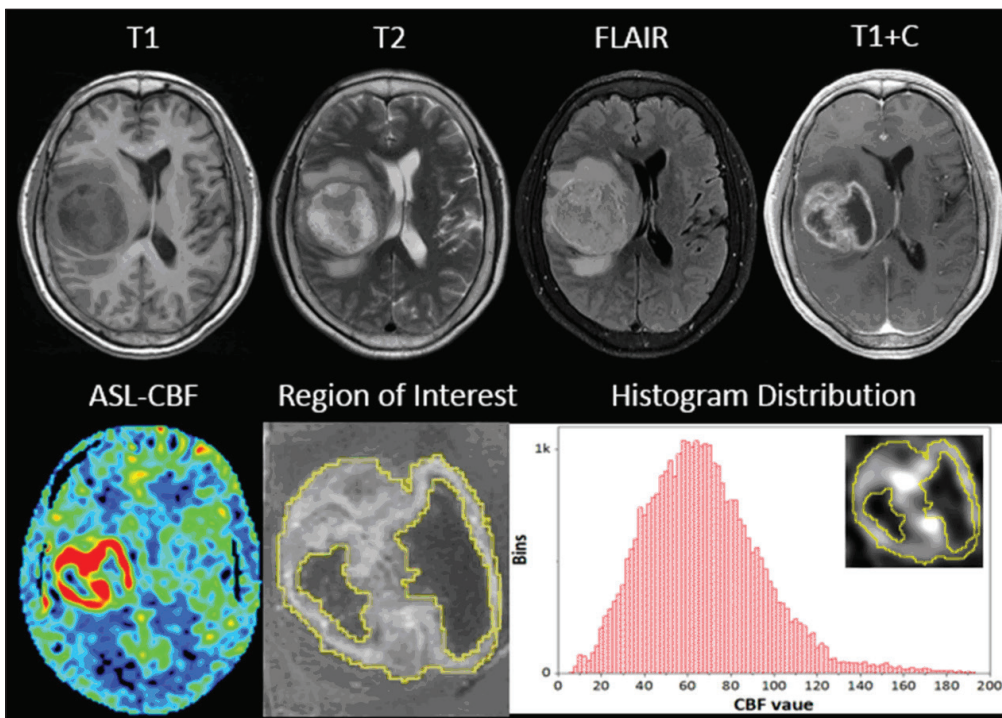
Representative case of isocitrate dehydrogenase wild-type and grade IV gliomas. A 63-year-old woman with glioblastoma (grade IV). The lesion with a heterogeneous signal of iso- or hyper-intensity on T2-weighted imaging was surrounded by edematous tissues. Necrosis was clearly observed with a peripheral ring or patchy enhancement. A representative region of interest was overlaid on contrast-enhanced T1-weighted MRI. Increased perfusion can be observed with a relatively higher central value of the histogram map.
